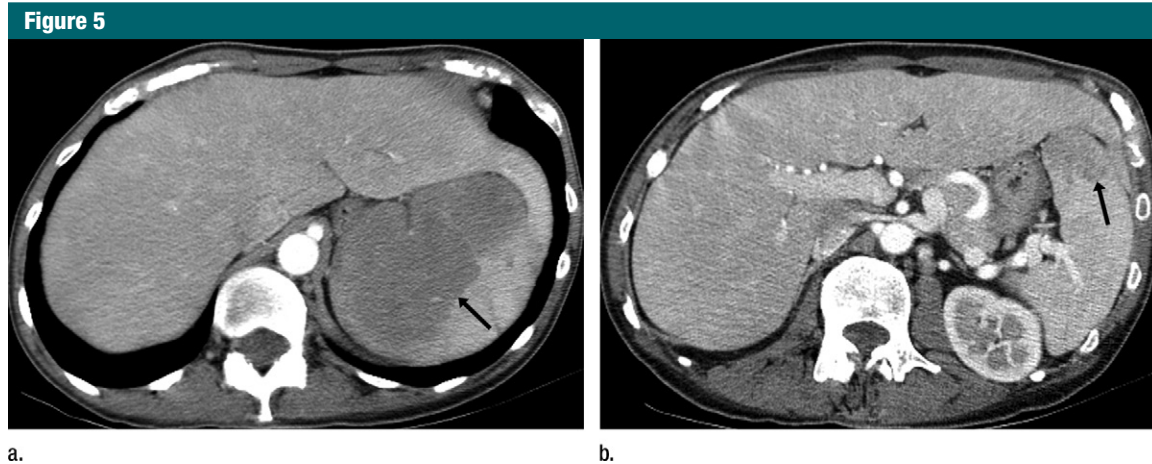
Images in a 49-year-old woman with fever and malaise. Axial CT images of the abdomen and pelvis with intravenous contrast material raised concern for new diagnosis of lymphoma. (a) Large mass (arrow) involves superior aspect of spleen. (b) Second smaller mass (arrow) is noted at inferior aspect of spleen. Lymphoma was confirmed at splenectomy.
